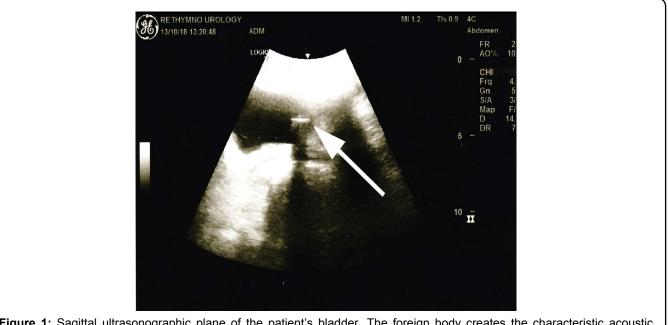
Sagittal ultrasonographic plane of the patient's bladder. The foreign body creates the characteristic acoustic shadow (white arrow).
